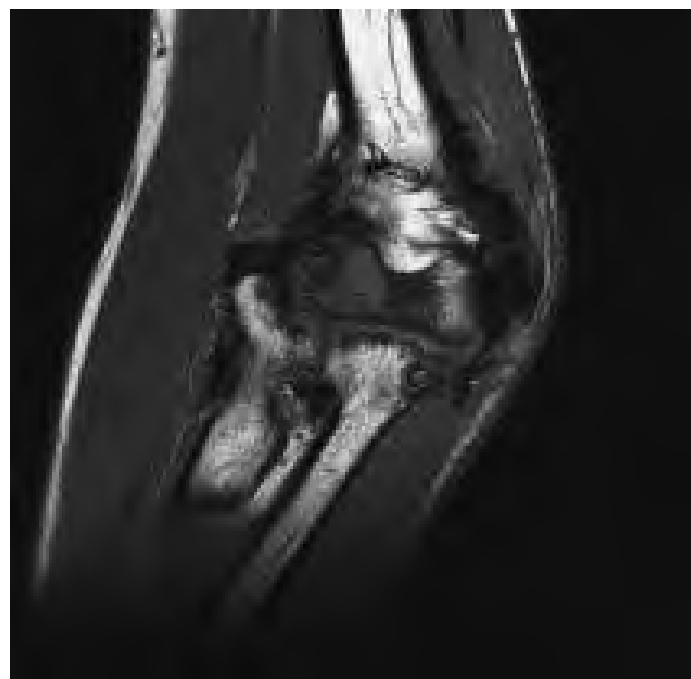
MR image of the Elbow.
